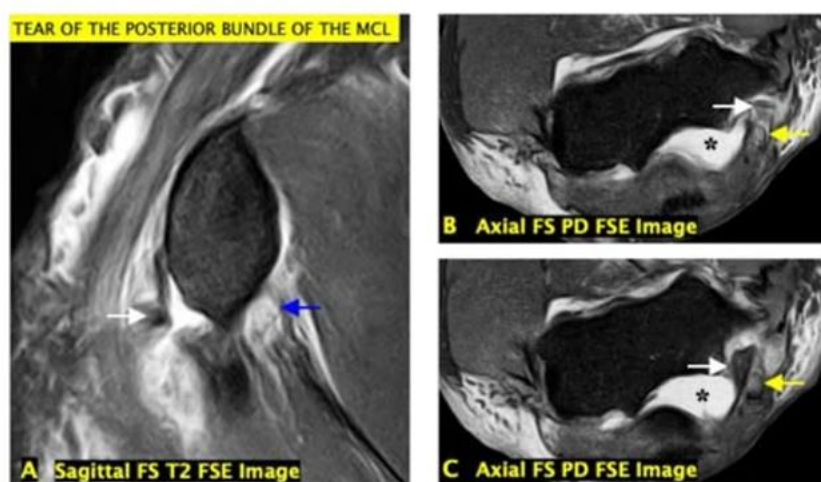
MRI findings of ulnar neuropathy secondary to posterior bundle MCL avulsion. (A–C) MR images demonstrate acute avulsion of the posterior bundle of the medial collateral ligament (MCL), with retraction of the osseous fragment (white arrow) causing mass effect and secondary subluxation of the ulnar nerve (yellow arrows). Associated findings include ulnohumeral incongruity with joint effusion (*) and a common flexor tendon full-thickness tear (blue arrow in A).
